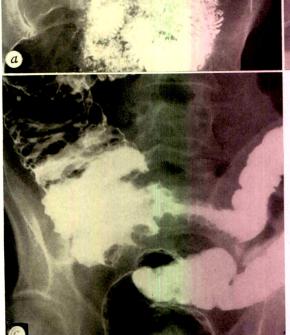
Three cases of adenocarcinoma demonstrating characteristic roentgenographic appearance. (a and b) Short, sharply demarcated, annular defect in third portion of duodenum. There is partial obstruction. (c) Similar lesion in jejunum demonstrating loss of normal pattern of mucous membrane throughout extent of tumor. (d) Similar lesion showing irregular channel through annular lesion and evidence of partial obstruction.
